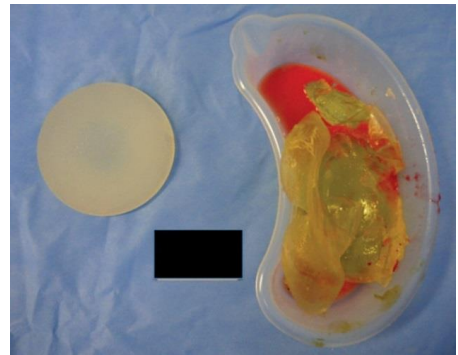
A pair of explanted Poly Implant Prothèse implants inserted in 2008 in the submuscular plane in which ultrasonography had diagnosed an otherwise asymptomatic rupture. As can be seen, surgical exploration revealed both complete elastomer disintegration and filler gel discoloration (on the right).
